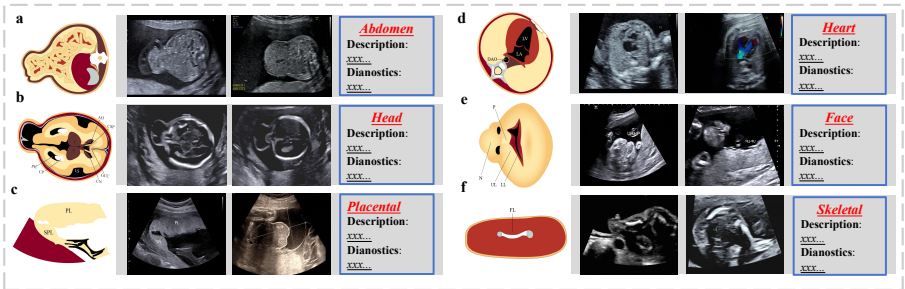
Example of 6 types of diseases detected by prenatal ultrasound.
